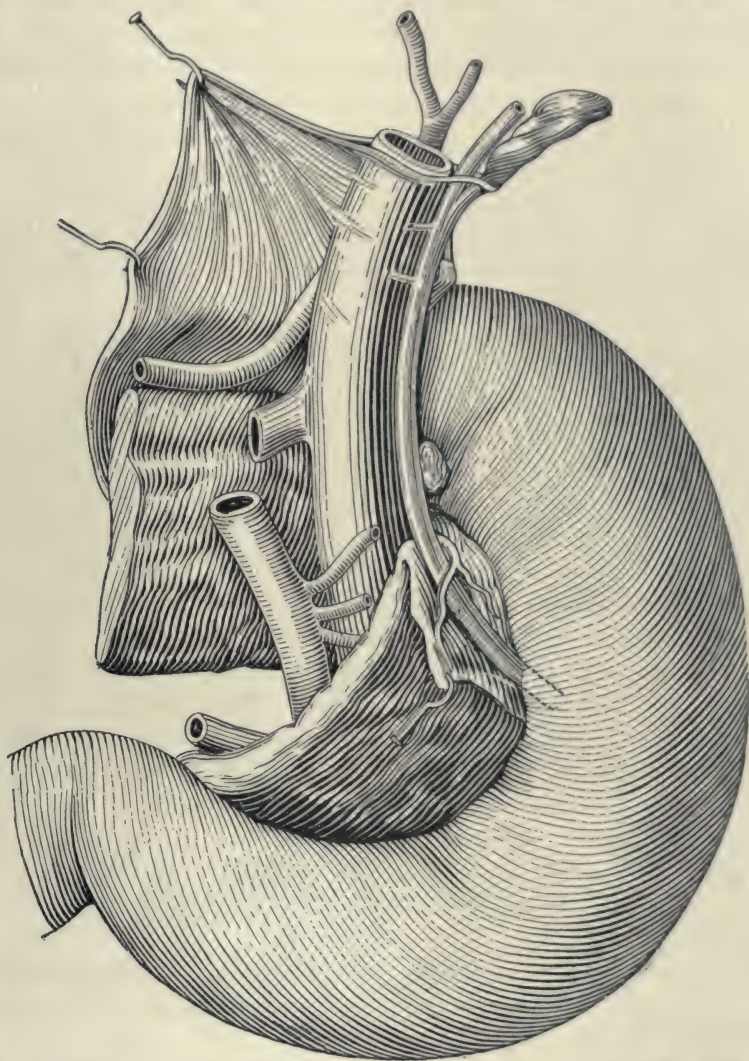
POSTERIOR ASPECT OF THE HEAD AND ISTHMUS OF THE PANCREAS. (Testut.)
